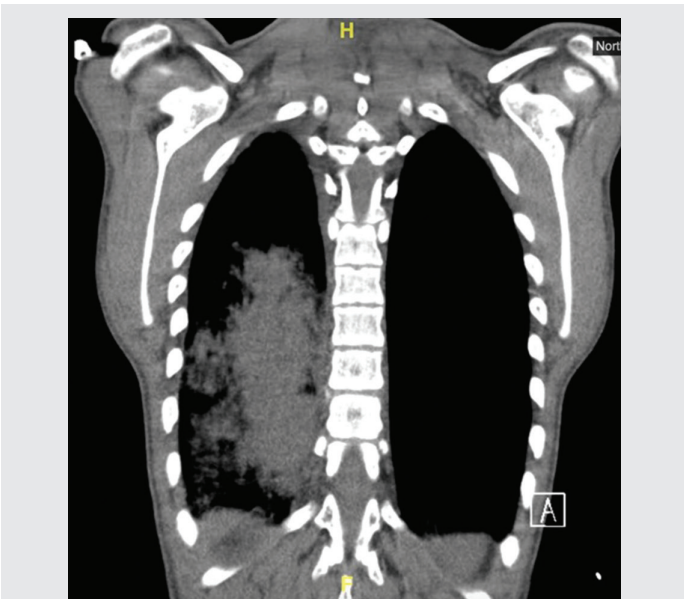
Computed tomography scan of the chest (coronal plane) reveals a RLL infiltrate.
